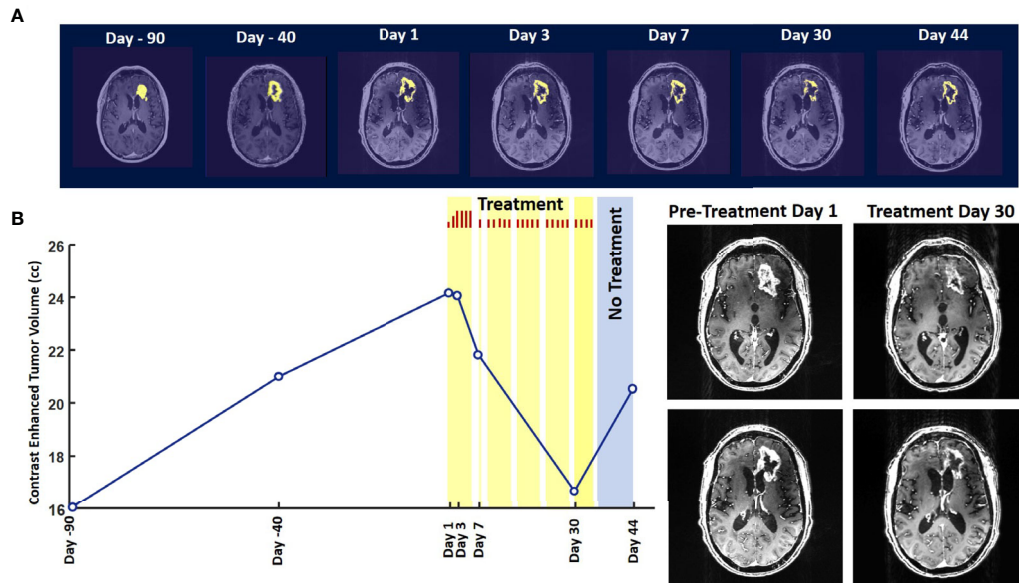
Change in Contrast-Enhanced Tumor Volume. (A) T1-weighted axial post-contrast scans showing the contrast-enhanced tumor (CET) highlighted with an overlaid automated computer program-generated light-yellow mask at different time points (B) Left – A graph showing the change in CET volume over time. The treatment times and durations are shown as red bars and light-yellow highlights. The long pause in treatment is shown as a light-blue highlight. Right – T1-weighted axial post-contrast scans showing CET at two levels along the dorso-ventral axis at Day 1 before treatment and Day 30 of treatment.
